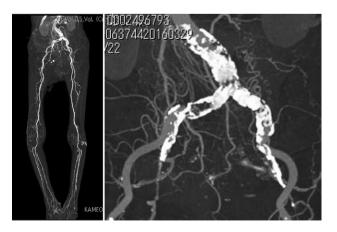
CT angiography showing total occlusion around the aorto-iliac bifurcation with severe calcification. The right side is the magnified image of the lesion.
